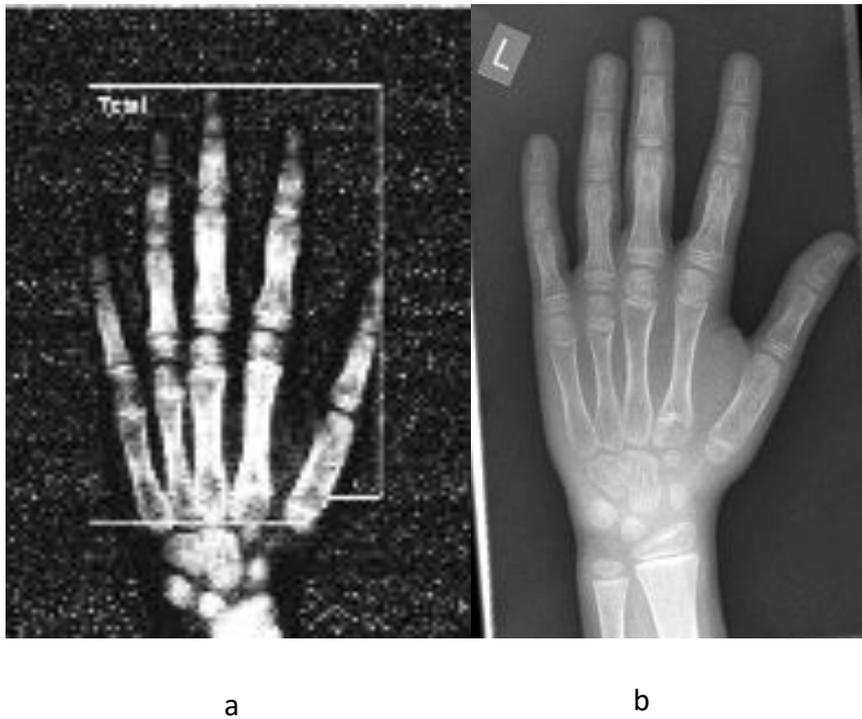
Example of poor quality DXA image with corresponding radiograph for comparison (male; 8 years 8 months old) (a) left hand DXA, (b) left hand radiograph
